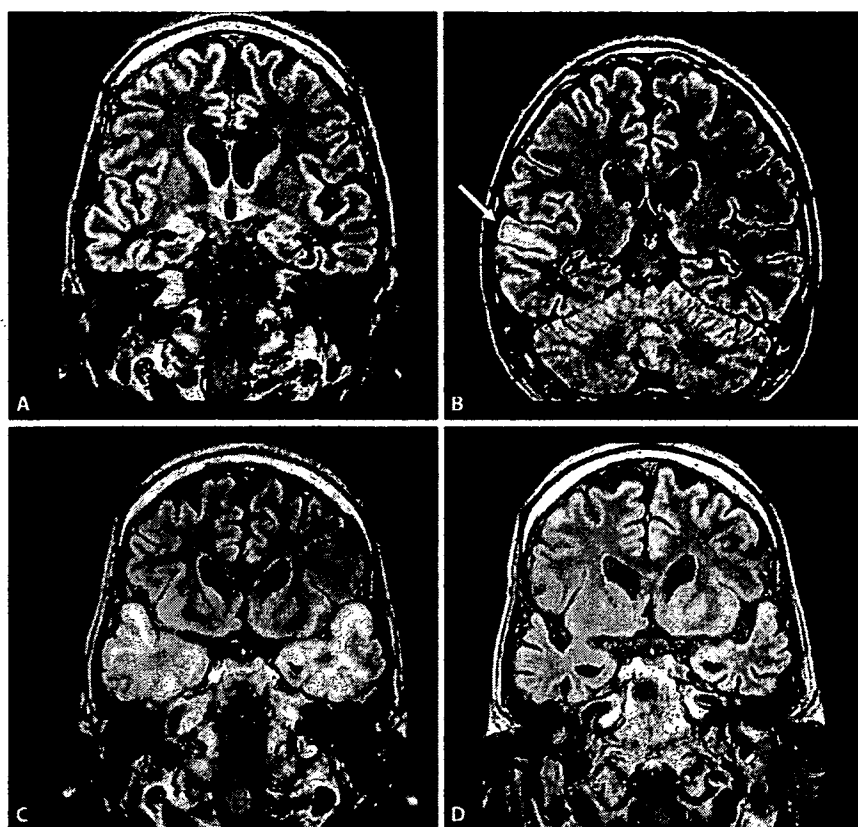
Coronal FLAIR MRI sequences. A Day 4: diffuse cerebral atrophy is seen, especially in the mesial temporal lobes including the hippocampi. B Day 13: a new area of high signal intensity is centered in the right superior temporal gyrus. C Day 46: severe signal alteration with edema affects extensive areas of the temporal lobes. D Day 172: abnormal signal disappeared and brain atrophy remained the same as on day 4 (A).
